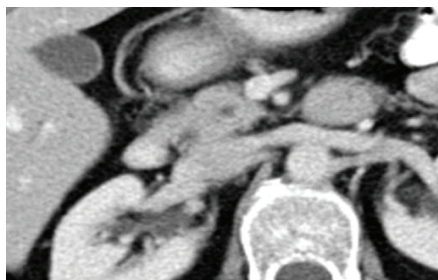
CT of the pancreas- portal phase: Focal fatty infiltration
